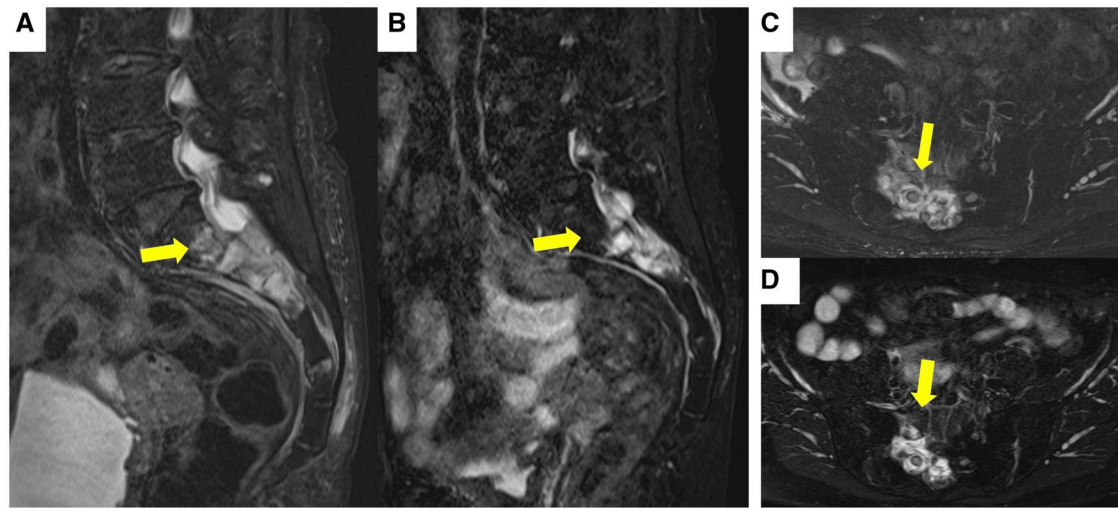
MRI following MTX withdrawal. (A, C) The tumour, which had penetrated intra- and extra-anteriorly up to the S1-3 level of the right sacral bone, reduced in size 3 months after MTX withdrawal. (B, D) MRI after 1 year from MTX withdrawal. The tumour, which was primarily intrasosseous at the S1-3 level of the right sacrum and had developed extraosseously in the anterior direction, was even further reduced in size.
